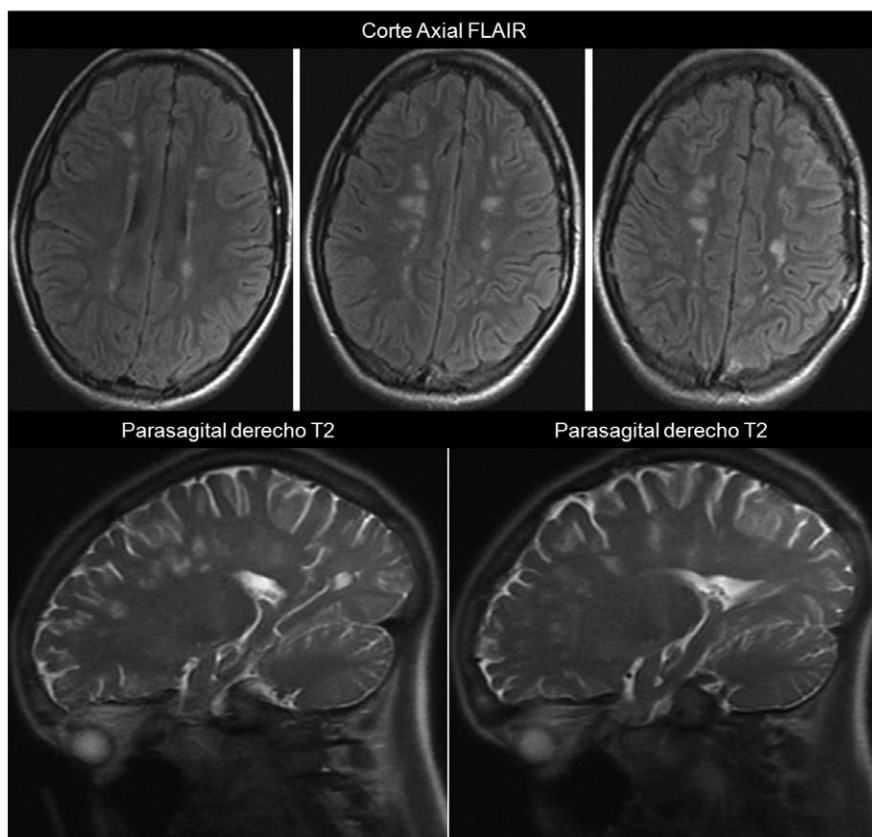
Brain MRI showed hypodense focal lesions in the white substance and in the periependymal region that enhance with contrast, without mass effect.
